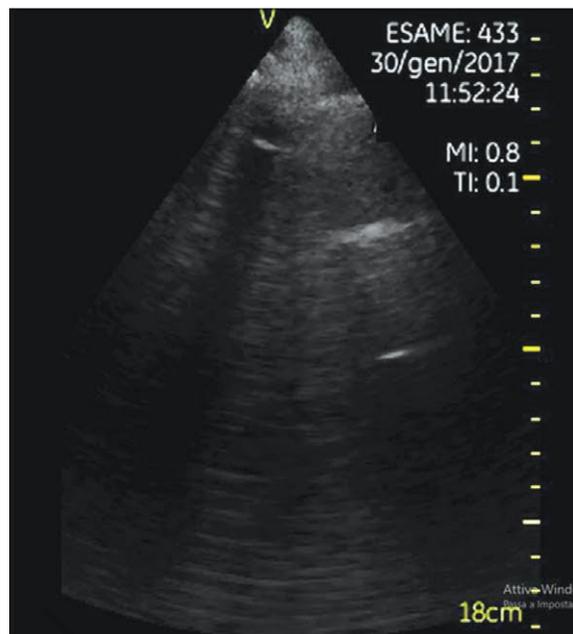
Case 1: Lung ultrasound (right lung) showing B-profile pattern-interstitial syndrome.
